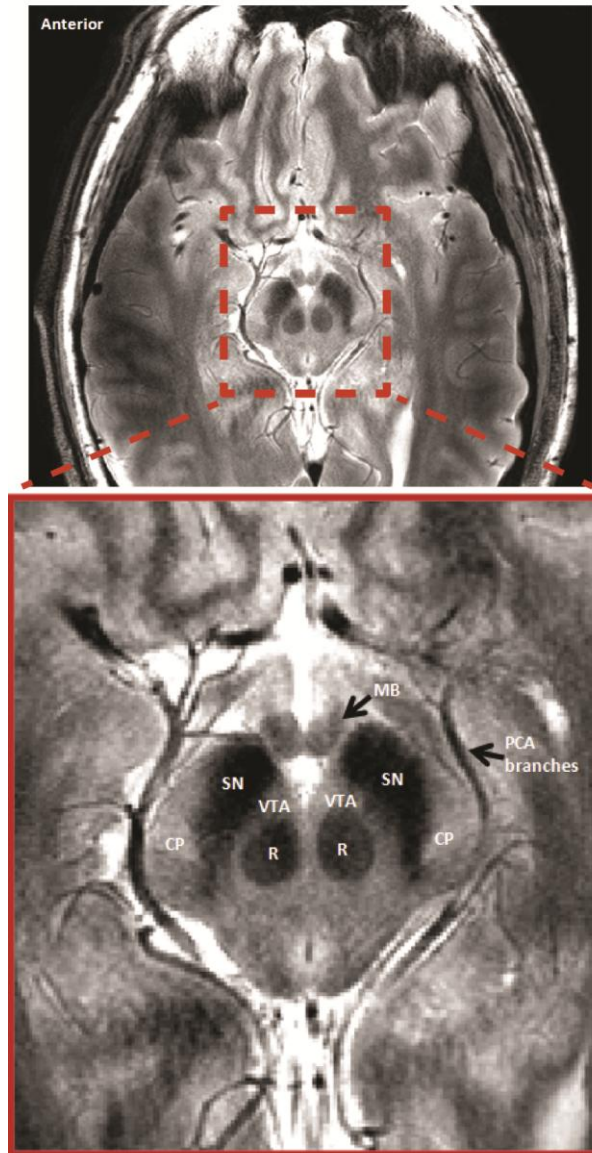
Axial slice from a GRASE MRI sequence at 7 T. The image represents a section through the midbrain at the level of the superior colliculus. Inset represents a zoomed version of the image, highlighting the midbrain. Legend of structures include: SN: Substantia Nigra; VTA: Ventral Tegmental Area; R: Red Nucleus; CP: Cerebral Peduncles; MB: Mammillary Body and PCA: Posterior Cerebral Artery.
